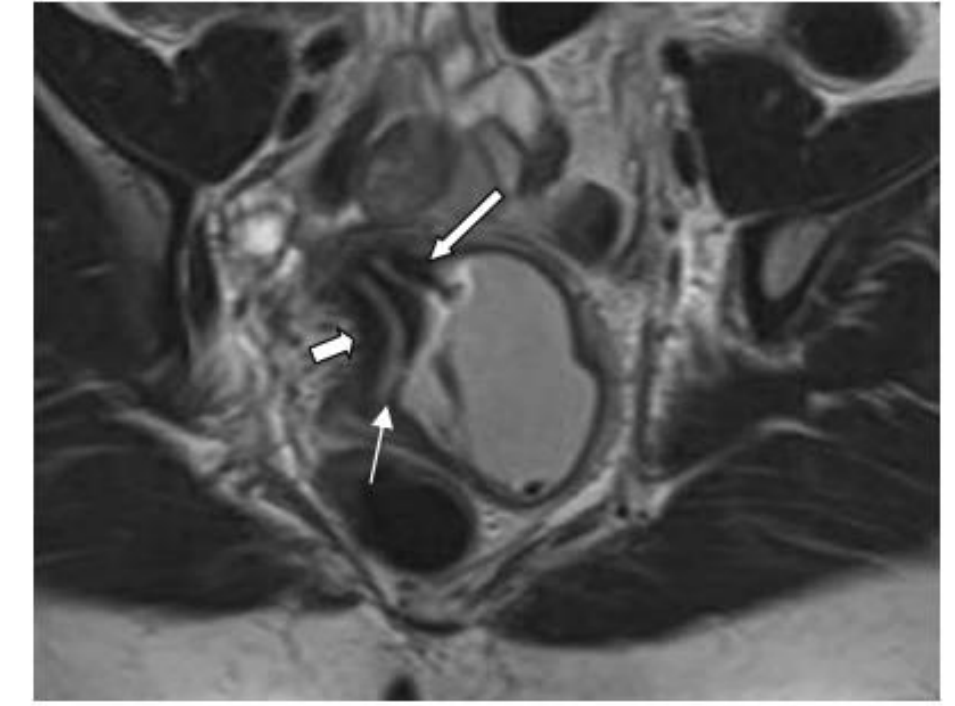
MRI scan (paracoronaral T2-weighted image) before excision of the obstructive septum: left cervix (*long arrow*) draining into the blind hemivagina and right cervix (*short arrow*) draining to normal right hemivagina, with connection between the two hemitraits (*thin arrow*)
